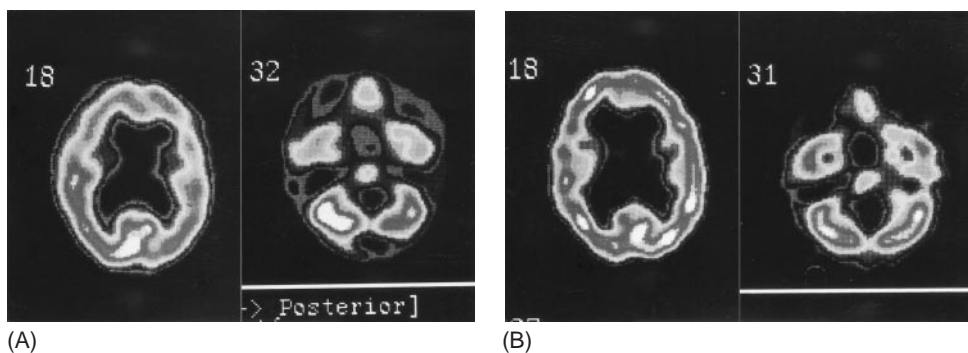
(A) ^{99m}Tc -HMPAO SPECT of the brain performed during a 3-week period of akinetic mutism following posterior fossa surgery. In addition to a pronounced relative (anteroposterior) bifrontal hypoperfusion, a marked relative hypoperfusion in the left hemisphere of the cerebellum is shown. (B) Repeated SPECT performed during the early phase of recovery from akinetic mutism reveals clearly improved perfusion of the frontal lobes with minimal perfusion decrease in the parietal lobe of the left cerebral hemisphere. A slight asymmetry of the cerebellar hemisphere persists (relative hypoperfusion of the left cerebellar hemisphere).
